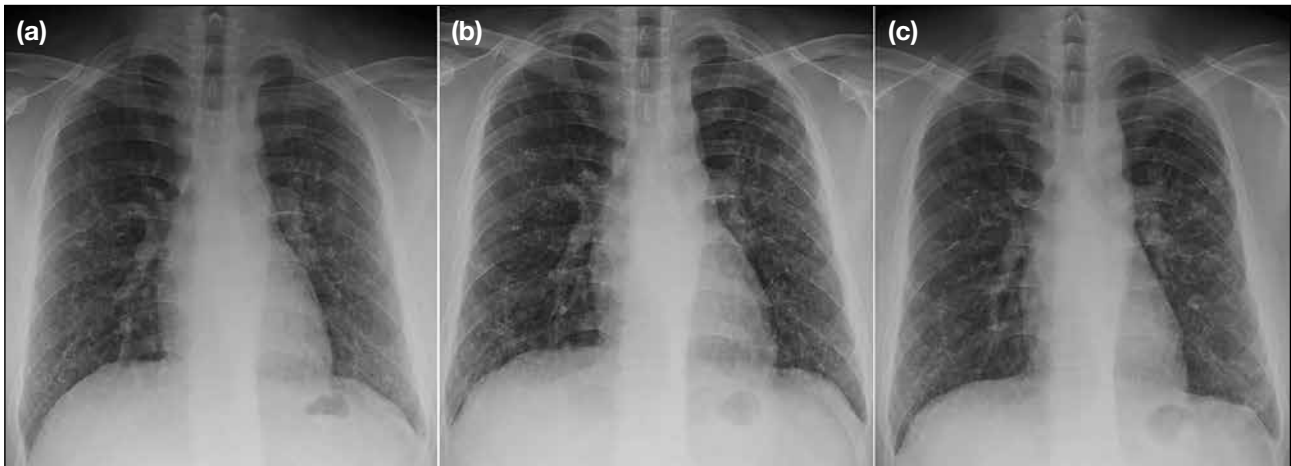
Chest radiographs in frontal projection. (a) Scan performed when the patient first presented to the Accident and Emergency department (AED) at the age of 23 years showing reticulonodular shadows over both lungs with basal predominance. (b) Scan performed when the patient presented to the AED at the age of 27 years showing mild interval progression of bilateral pulmonary reticulonodular shadows. (c) Scan performed at the age of 28 years, 1 year after pathological confirmation of dendriform pulmonary ossification, showing no significant interval progression.
